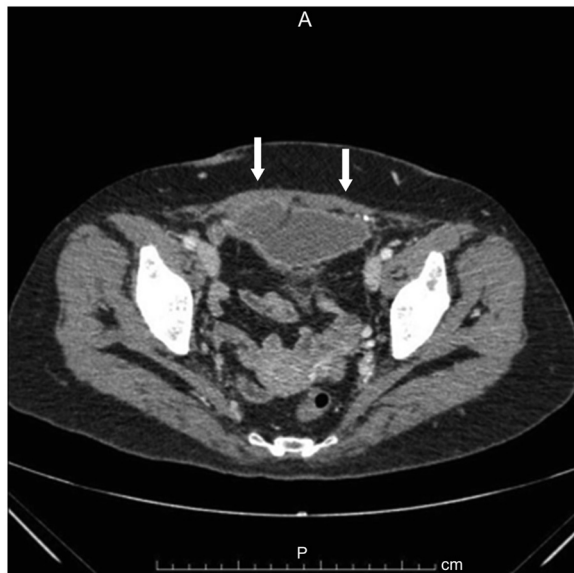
A: Follow-up enhanced abdominal computed tomography performed 3 months later reveals that both hematomas have decreased in size/.
